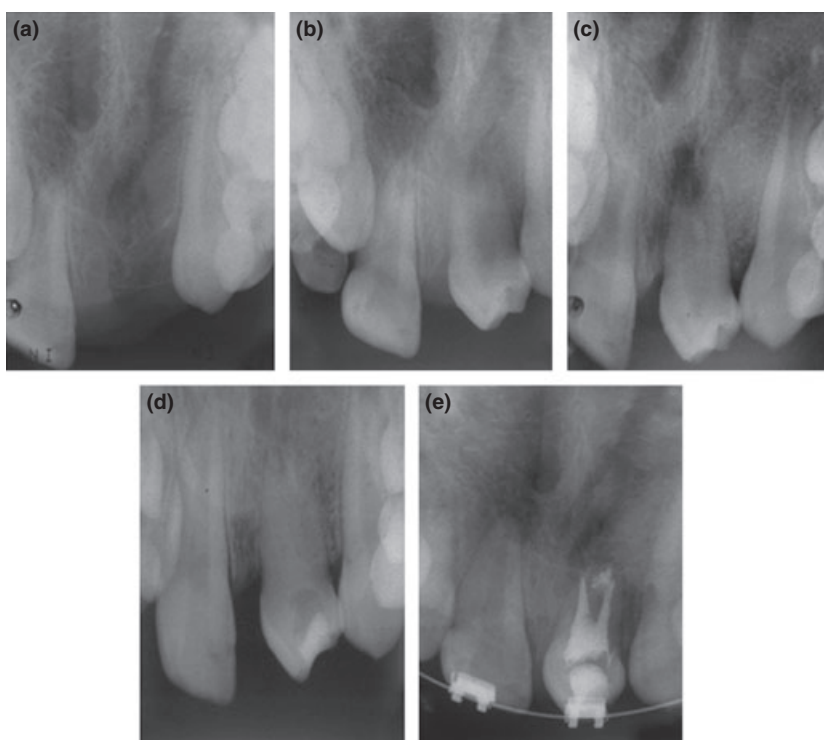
(a) Radiography previously to the autotransplantation. (b) One month follow up of the autotransplanted tooth. (c) Six months follow up of the autotransplanted tooth. (d) Nine months follow up of the autotransplanted tooth. (e) One year follow up of the autotransplanted tooth.
